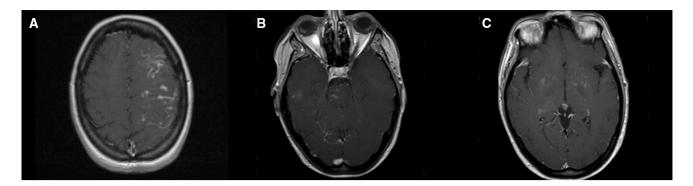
a Axial post contrast T1-weighted magnetic resonance image (MRI) demonstrates diffuse cortical and leptomeningeal enhancement over the left cerebral hemisphere. b Axial post contrast T1-weighted
